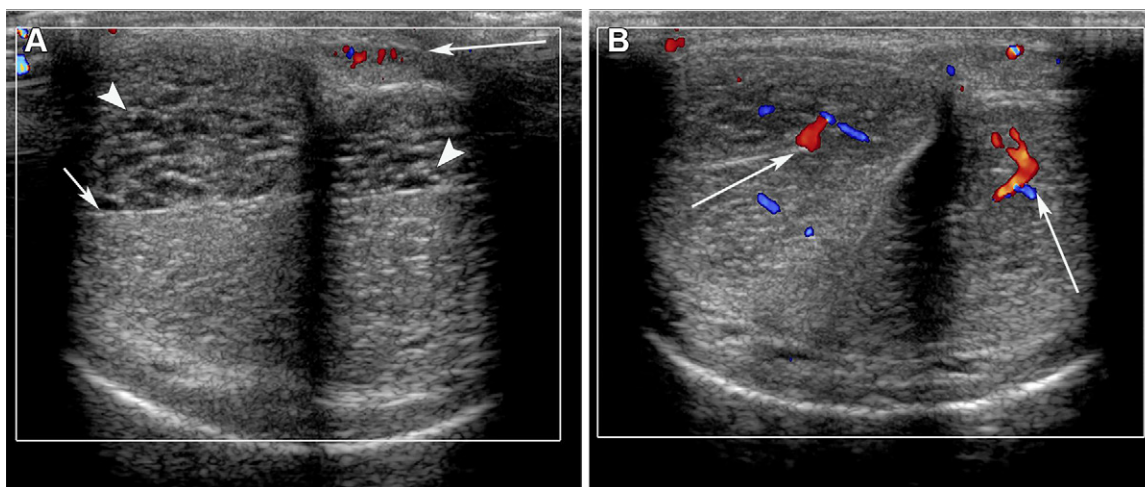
Priapism, increasing pain, and a rigid penis in a 37-year-old man 3 hours after pharmacologic induction of erection with intracavernosal injection of prostaglandin E1 for evaluation of ED. (A) Transverse color Doppler US image shows absent color flow in the dilated sinusoids (arrowheads) of the corpora cavernosa and a hematocrit level (short arrow) from stagnant blood. Note preserved flow in the dorsal penile artery (long arrow). (B) Transverse color Doppler US image acquired immediately after aspiration of 2–3 mL of blood from the cavernosa using a 25-gauge needle shows return of vascularity in the corpora cavernosa (arrows) and decompressed sinusoidal spaces. Immediate detumescence occurred after the aspiration.
